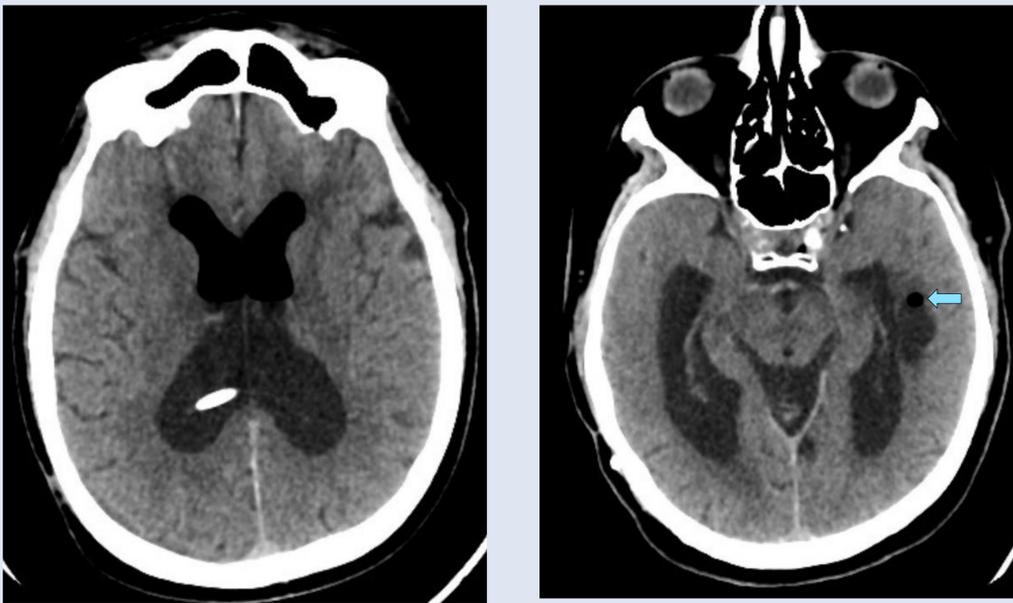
CT in the emergency department showing massive intraventricular pneumocephalus and a porencephalic cyst in the left temporal lobe (blue arrow).
